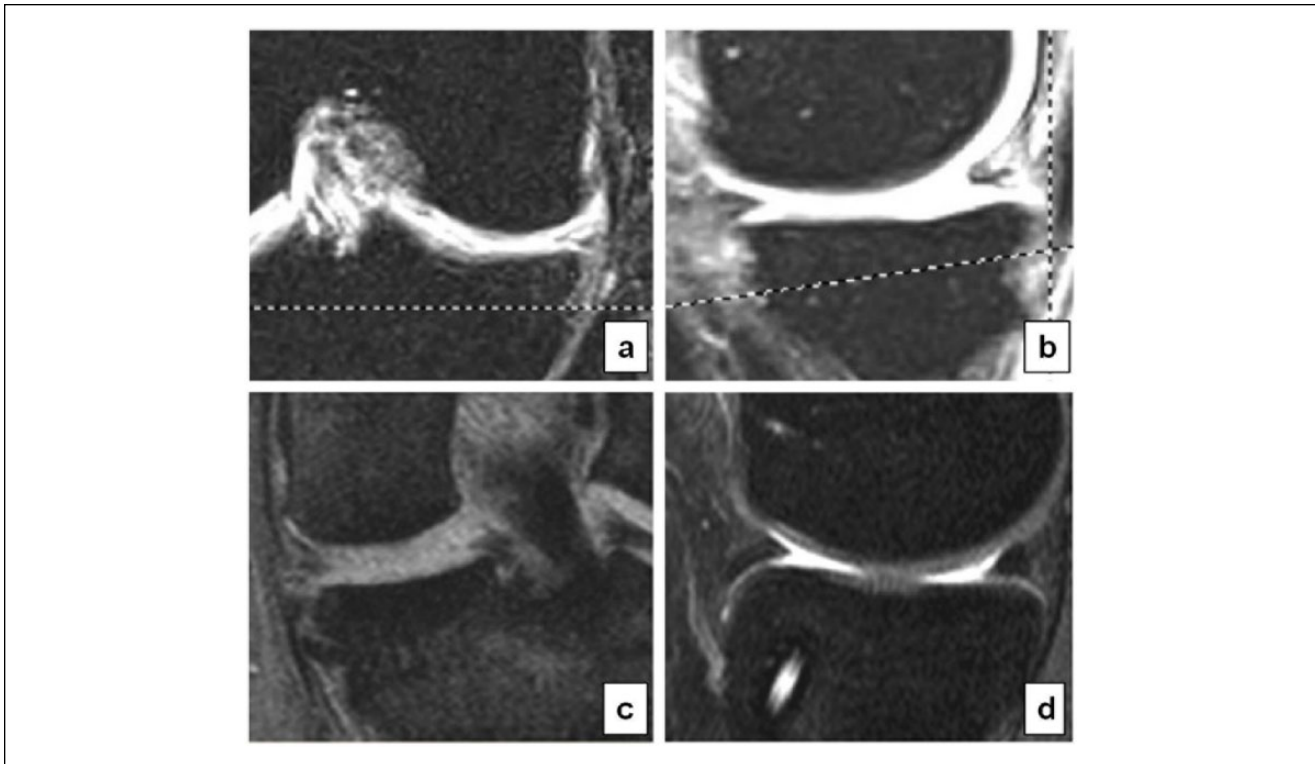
MRI of the 2 scaffolds with 2-year follow-up (CMI a-b, Actifit c-d); both the scaffolds are well positioned and well integrated. Both the scaffolds have irregular shape and different signals than the native meniscus.
